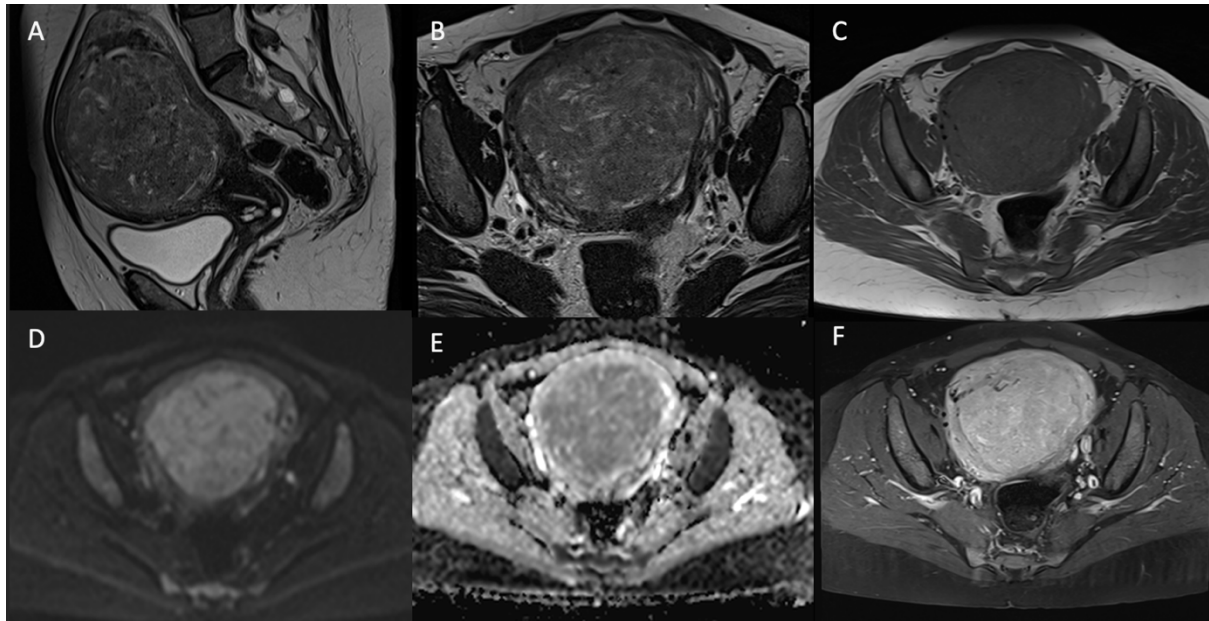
Forty-five-year-old female patient complaining of abnormal vaginal bleeding. A B Sagittal and axial T2WI showed a heterogenous hyperintense lesion; C Axial T1WI revealed isointense lesion; D E Intermediate signal on DWI, lower than the endometrium and low signal on the ADC map. ADC mean value was $(1.054 \times 10^{-3} \text{ mm}^2/\text{s})$. F T1 FS postcontrast axial image with heterogeneous enhancement. Pathology revealed atypical leiomyoma.
